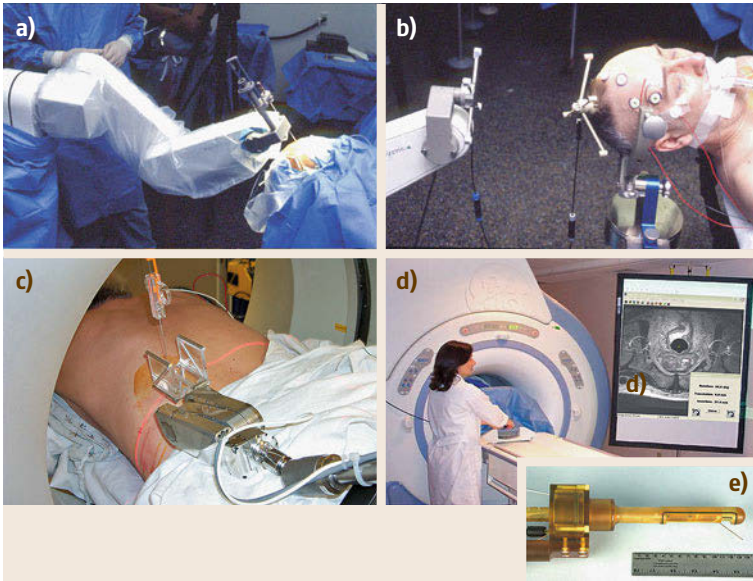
Clinically deployed systems for in-scanner needle placement. (a,b) The Neuromate system (after [63.19]) for stereotactic procedures in the brain uses a novel noncontact sensing system for robot-to-image registration; (c) Johns Hopkins system for in-CT needle placement (after [63.70, 71]); (d,e) Manually activated device for in-MRI transrectal needle placement into the prostate (after [63.72])
